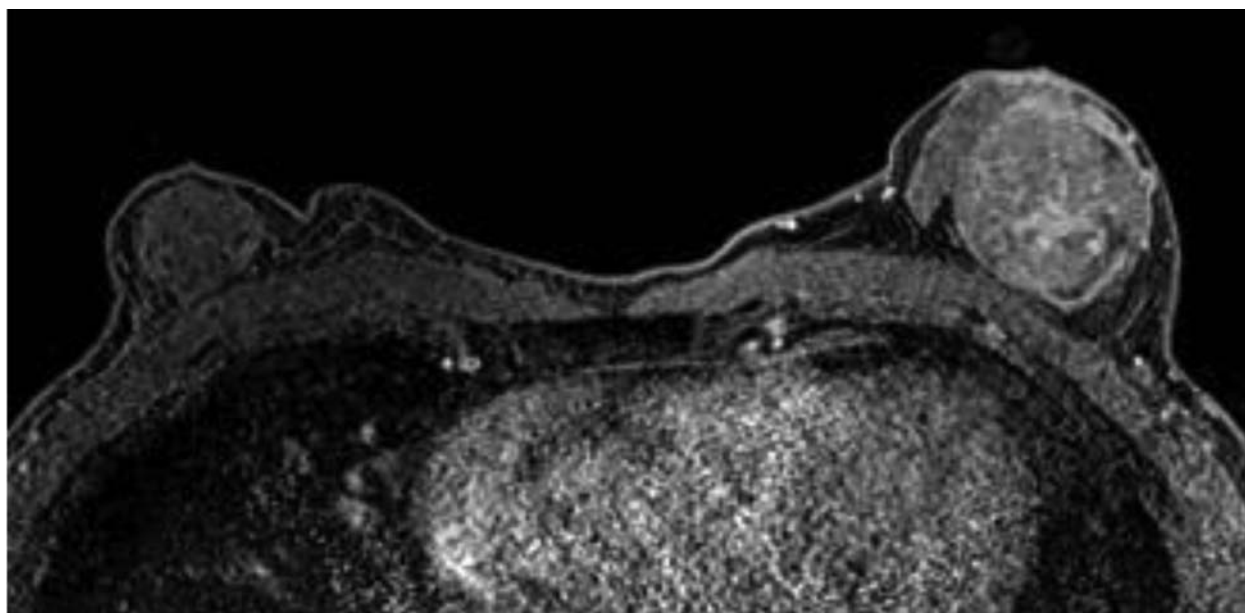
Axial T1-weighted magnetic resonance image, taken 300 sec after intravenous contrast injection, shows bilateral gynecomastia and a 45-mm well-circumscribed heterogeneously enhancing mass in the left breast.
